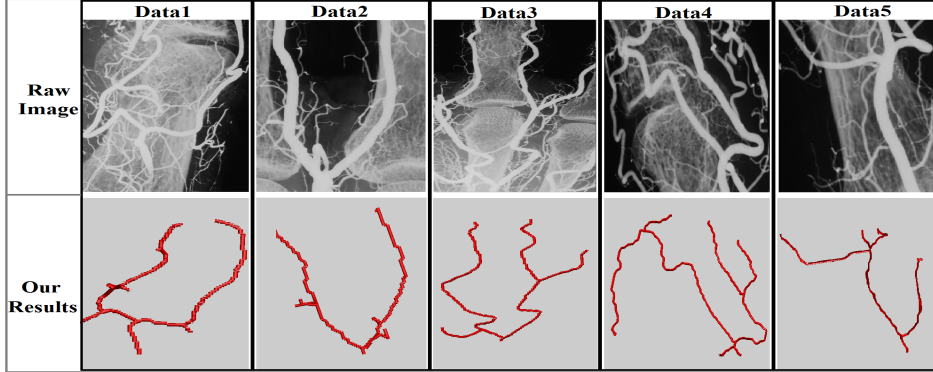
Experiments on 5 X-ray stereo images with bones. The first line shows 5 raw images, the second line shows their corresponding 3D rendering results using our method
